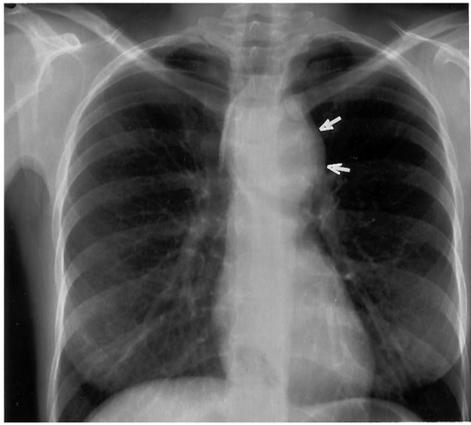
(Top) PA chest radiograph and (bottom) contrast-enhanced chest CT (mediastinal windows) at the level of the aortic arch in a 24-year-old man with acute stridor. A left paratracheal bronchogenic cyst causes mediastinal widening (white arrows) and mass effect on the airway. The nonenhancing, water attenuation cyst is interspersed between the aorta (a), esophagus (arrowhead), and trachea (black arrow), with moderately severe compromise of the airway.
